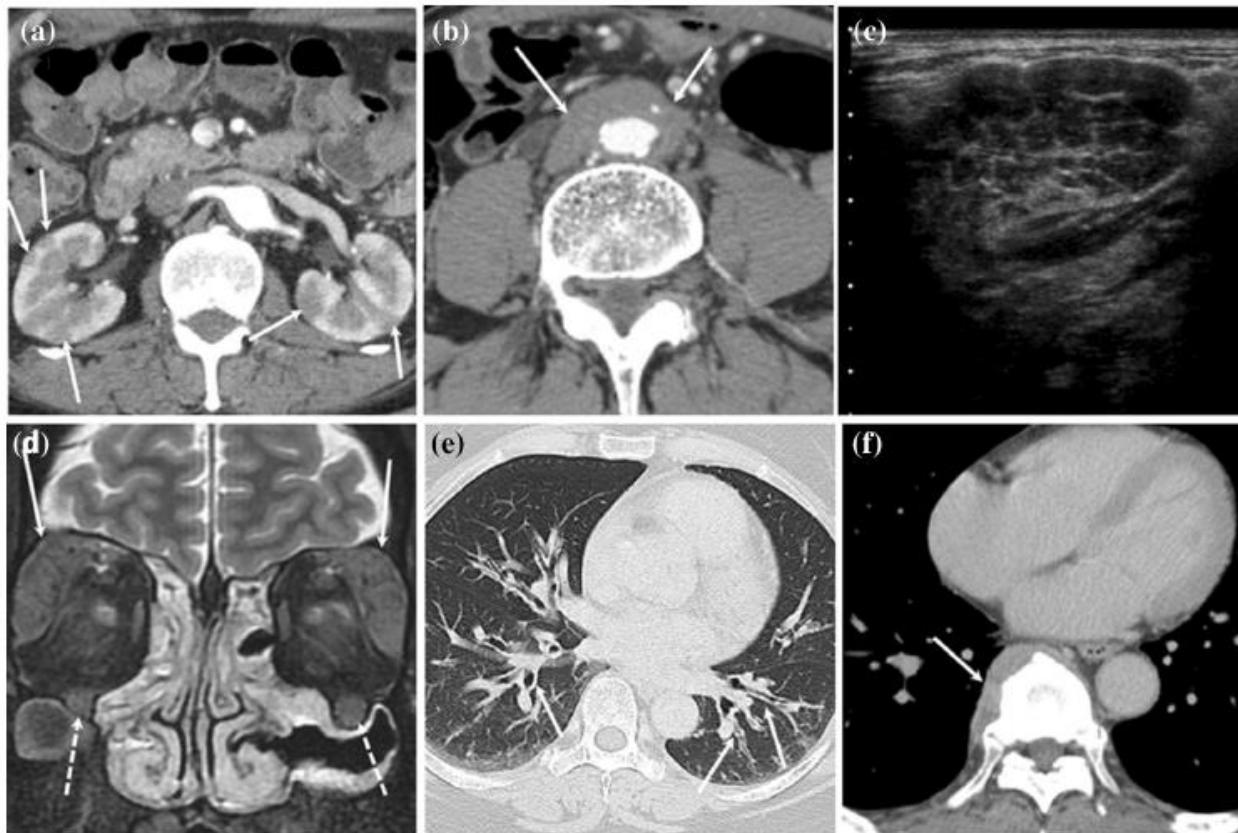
Various extrapancreatic manifestation of AIP. a 71-year-old male with type 1 AIP. CT of abdomen shows multiple wedge-shaped low-density areas in bilateral renal cortex (arrows) consistent with IgG4-related renal disease. b 69-year-old male with type 1 AIP. CT of abdomen shows circumferential wall thickening of the abdominal aorta (arrows) suggestive of periaortic IgG4-related disease. c 81-year-old male with type 1 AIP. Ultrasonography of the submandibular gland demonstrates enlarged gland with multiple low-echoic areas surrounded by linear hyperechoic structures. d 62-year-old
